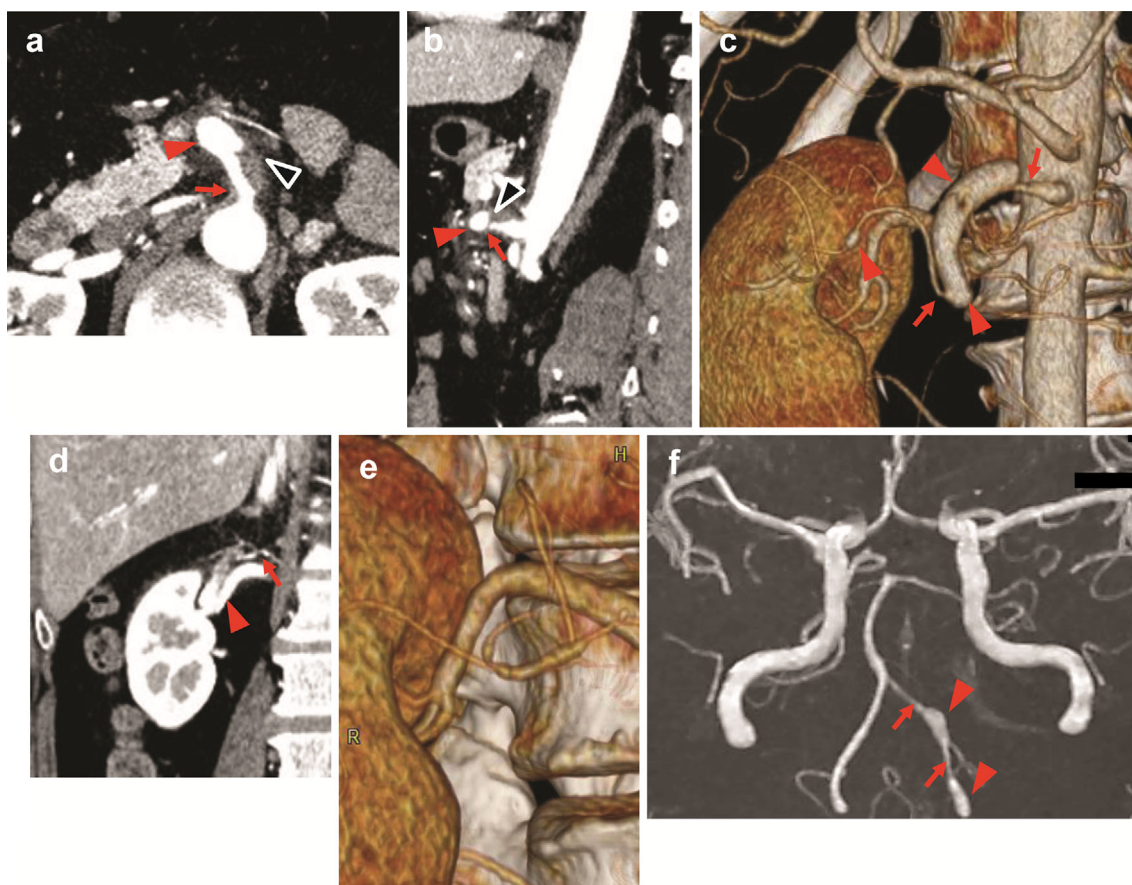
Imaging studies of FMD in Case 1. (a, b, c) Computed tomography (CT) and three-dimensional reconstruction showed stenosis (red arrows), aneurysmal changes (red arrowheads), and partially dissection (black arrowheads in a and b) in the superior mesenteric artery. (d, e) Stenosis (red arrows) and aneurysmal changes (red arrowheads) in the branch of the right renal artery. Magnetic resonance angiography showed stenosis (red arrows) and aneurysmal changes (red arrowheads) in the left vertebral artery (f). FMD: fibromuscular dysplasia
